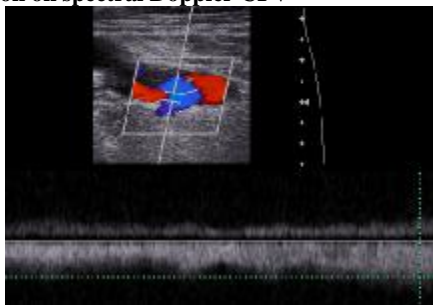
“Running channel Leakage channel” aliasing, colour filling defect, absence of respiratory and cardiac modulation on spectral Doppler CFV
